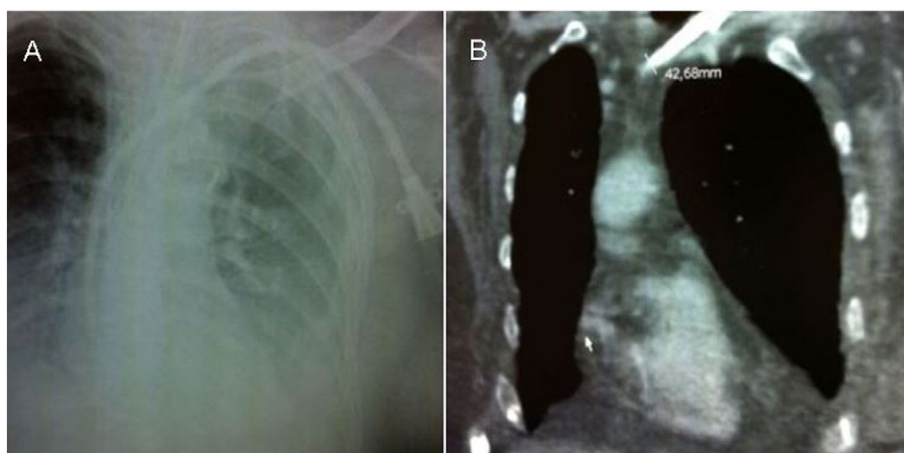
A chest radiography image (Panel A) and a tomography computed image (Panel B) showing the complete left subclavian dialysis catheter course and pleural effusion were also performed before its complete removal.
